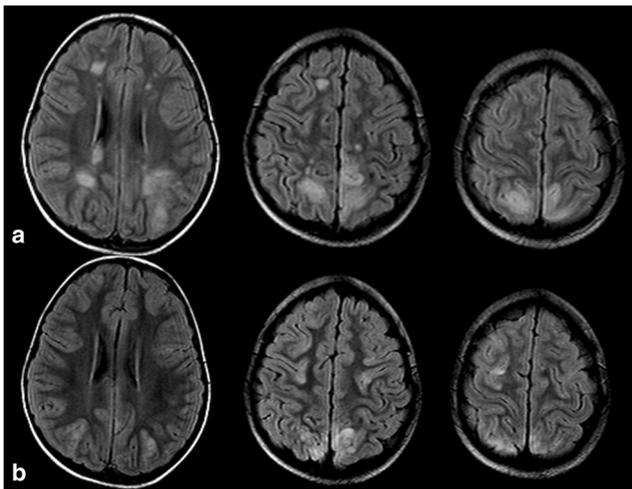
FLAIR MR images at onset (A) and at a distance of 5 days (B). Baseline MR confirms the presence of multiple small high-signal foci at gray matter-white matter junction. A more typical involvement of “watershed” cortical territories is present. Follow-up examination shows a significant reduction in lesion load (B)
